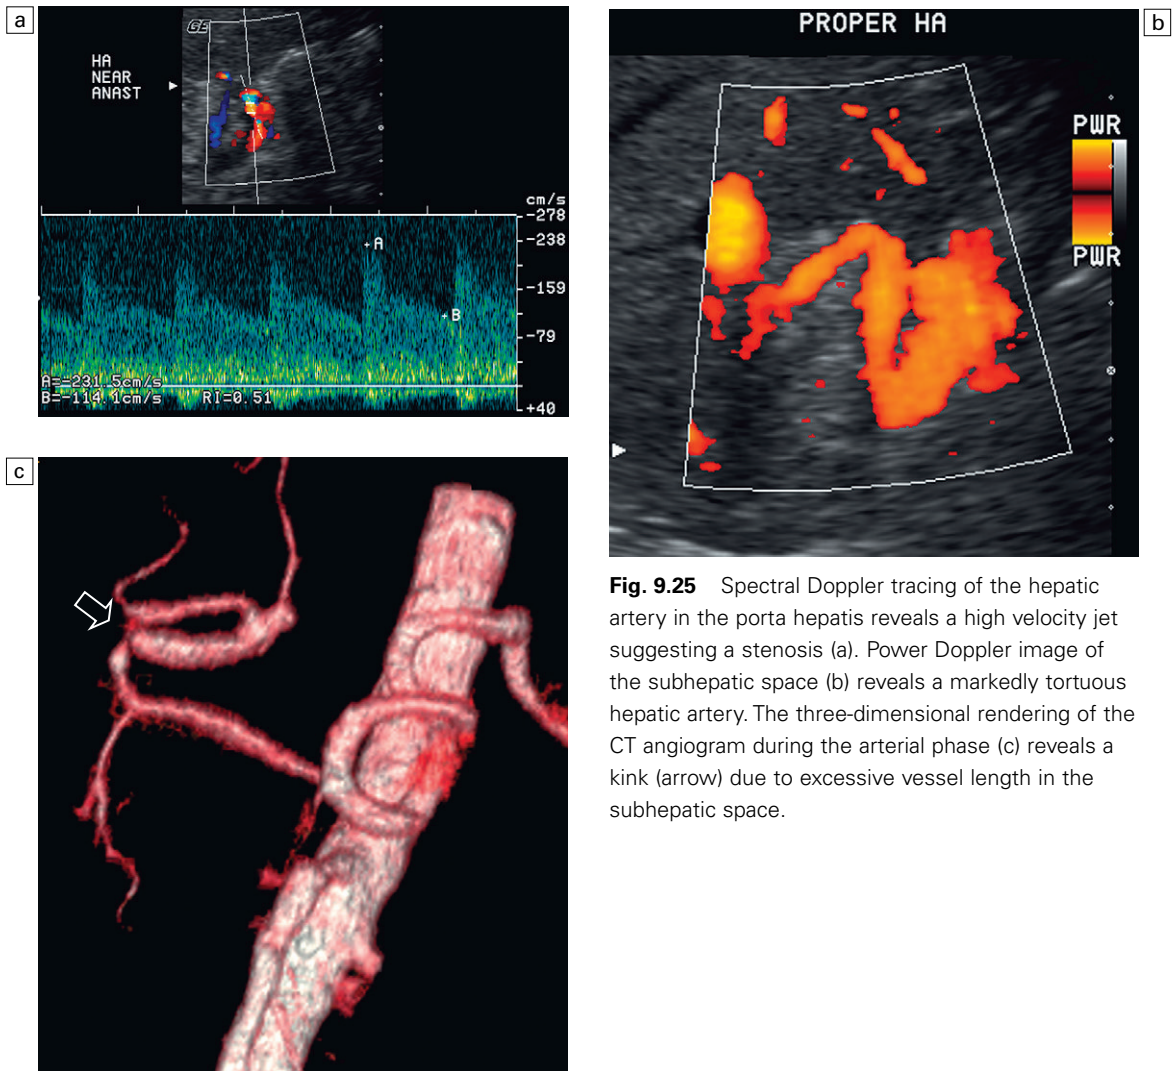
Spectral Doppler tracing of the hepatic artery in the porta hepatis reveals a high velocity jet suggesting a stenosis (a). Power Doppler image of the subhepatic space (b) reveals a markedly tortuous hepatic artery. The three-dimensional rendering of the CT angiogram during the arterial phase (c) reveals a kink (arrow) due to excessive vessel length in the subhepatic space.
